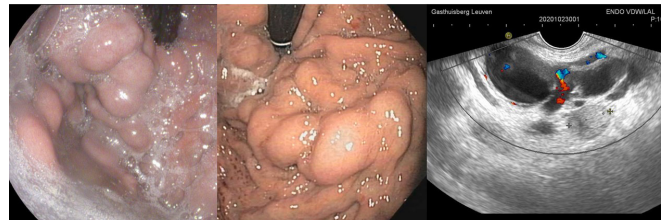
Gastro-fundal varices (IGV-1) shown on conventional endoscopy (left and middle) and upon endoscopic ultrasound (right).
